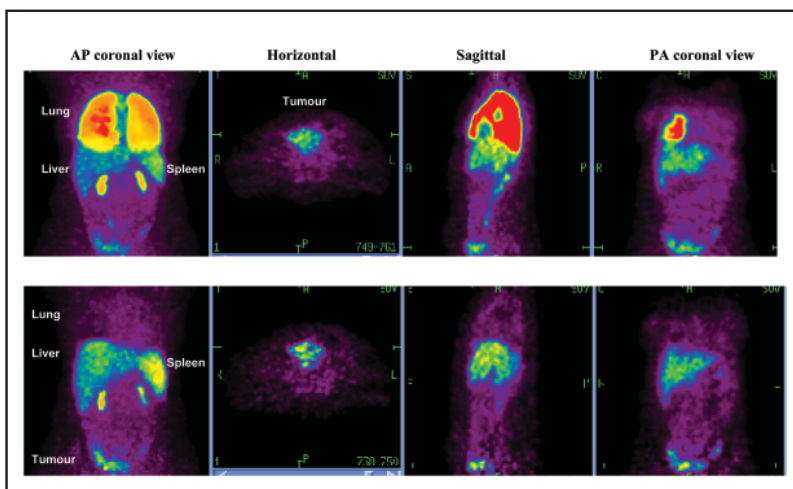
Cell tracking. Patient's modified effector cells have been labelled with F^{18} -fluorodeoxyglucose (FDG), infused intravenously, and scanned by positron emission tomography at 1 hour (upper panel) and 4 hours (lower panel). Following lung clearance, cells are seen to track to liver, spleen, and to the known site of tumor in the pelvis.
